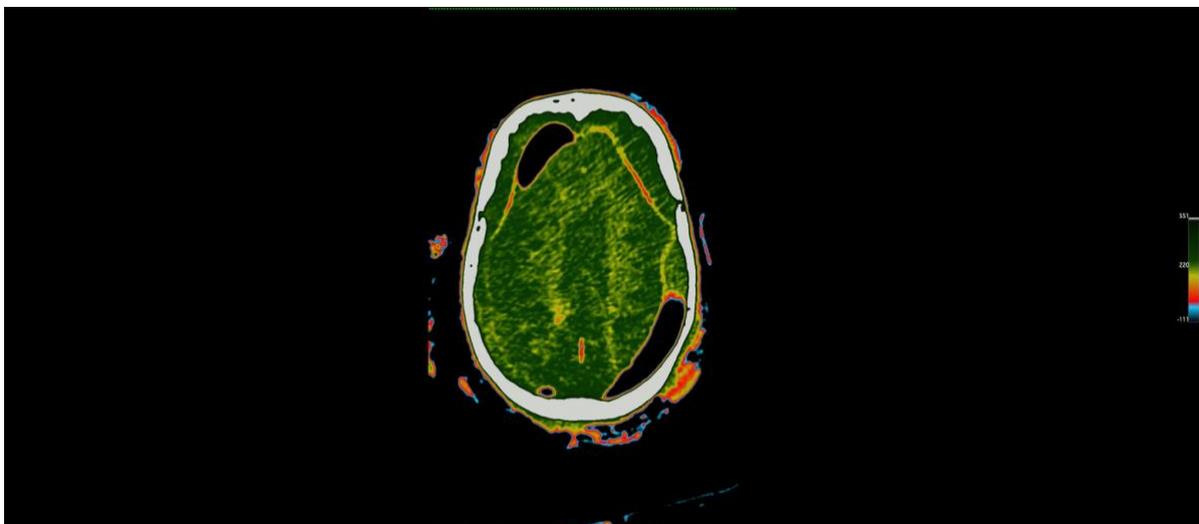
Axial plane CT slice 2.
